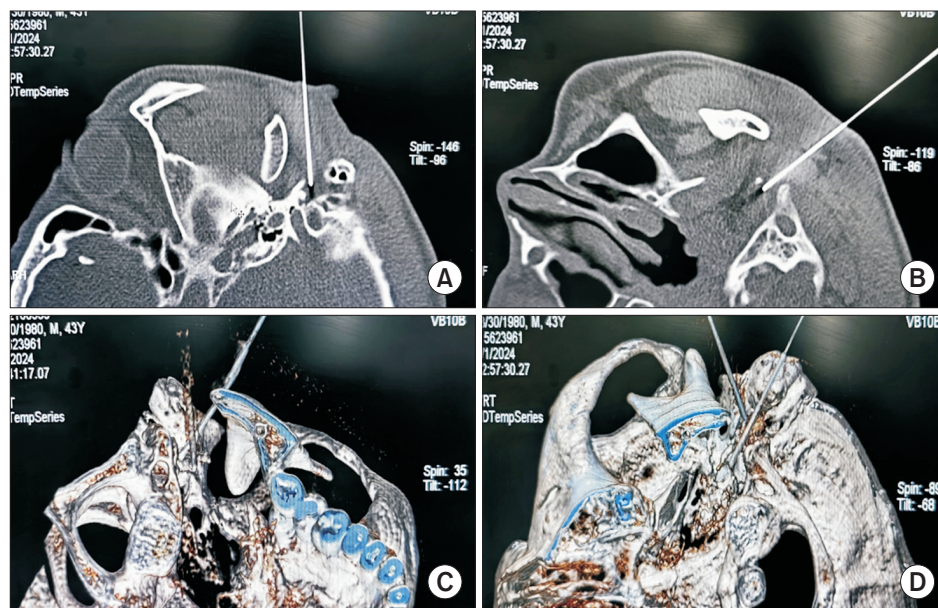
(A) CT-guided radiofrequency ablation of facial nerve by right stylomastoid foramen puncture to treat eyelid spasms, lip muscle spasms, or platysma twitches. (B) CT-guided radiofrequency ablation procedure of the accessory nerve by the posterior edge of the styloid process at the level of the upper edge of the right atlas transverse process to treat involuntary head-turning movements. (C) CT three-dimensional reconstruction image after successful puncture of the right facial and accessory nerves with right RF needle points located in the stylomastoid foramen and the posterior edge of the styloid process. (D) CT three-dimensional reconstruction image after successful puncture of the left facial and accessory nerves with left RF needle points located in the stylomastoid foramen and the posterior edge of the styloid process.
